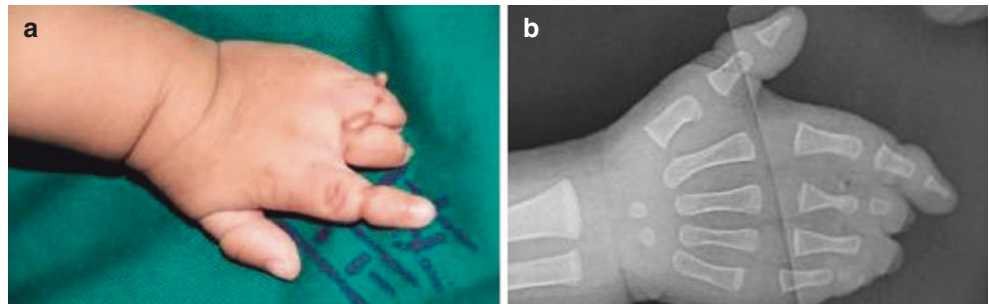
Type X thumb dysplasia. (a) Hand appearance. (b) X-ray findings
